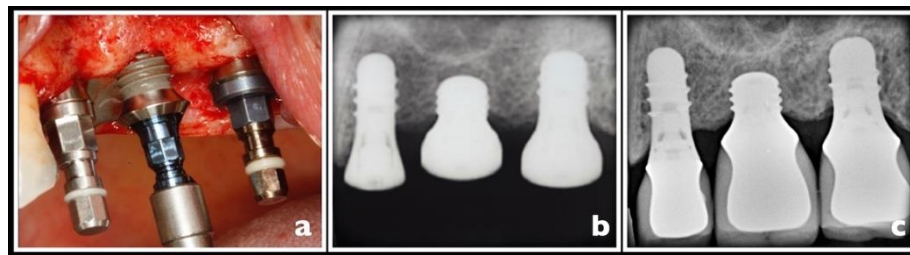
One of the 4-mm implants placed in the left maxilla of a male patient. (a) Operative moment. (b) Intraoral digital radiograph taken at the immediate post-operative period of implant insertion. (c) After a minimum time of 12 months post-loading with unsplinted metal-ceramic screw-retained crowns.
